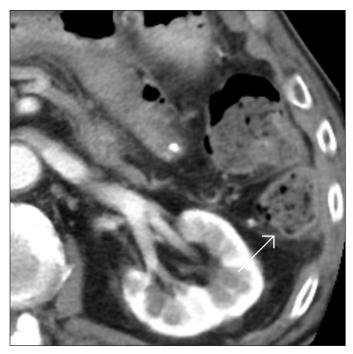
Abdominal CT showing (A) chronic pancreatitis with the splenic vein occlusion behind the tail of the pancreas, and (B) severe collaterals towards the descending colon.
